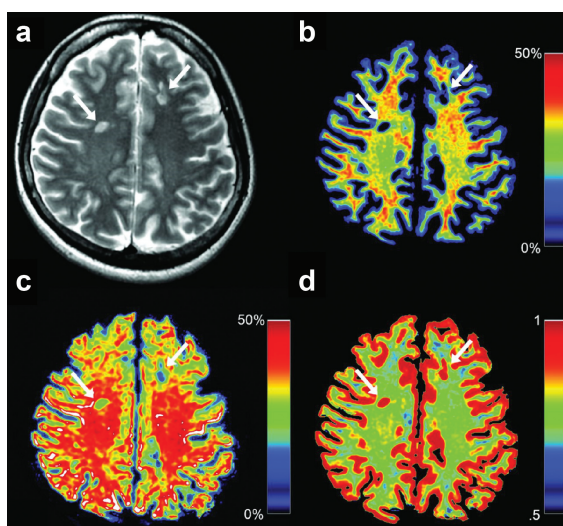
Representative images from a patient with MS. Synthetic T2WI (a) and maps of myelin volume fraction (b), axon volume fraction (c), and g-ratio (d) are shown. Two plaques are designated by arrows in these images. The myelin is severely damaged in these plaques (b, 5.53% and 7.23%); however, the degrees of axon damage are milder (c, 31.30% and 22.95%). Since the myelin is severely damaged in these plaques, the corresponding g-ratios are close to 1.00 (d, 0.94 and 0.91) (adapted from Fig. 1 of reference #48). T2WI, T2-weighted imaging.
